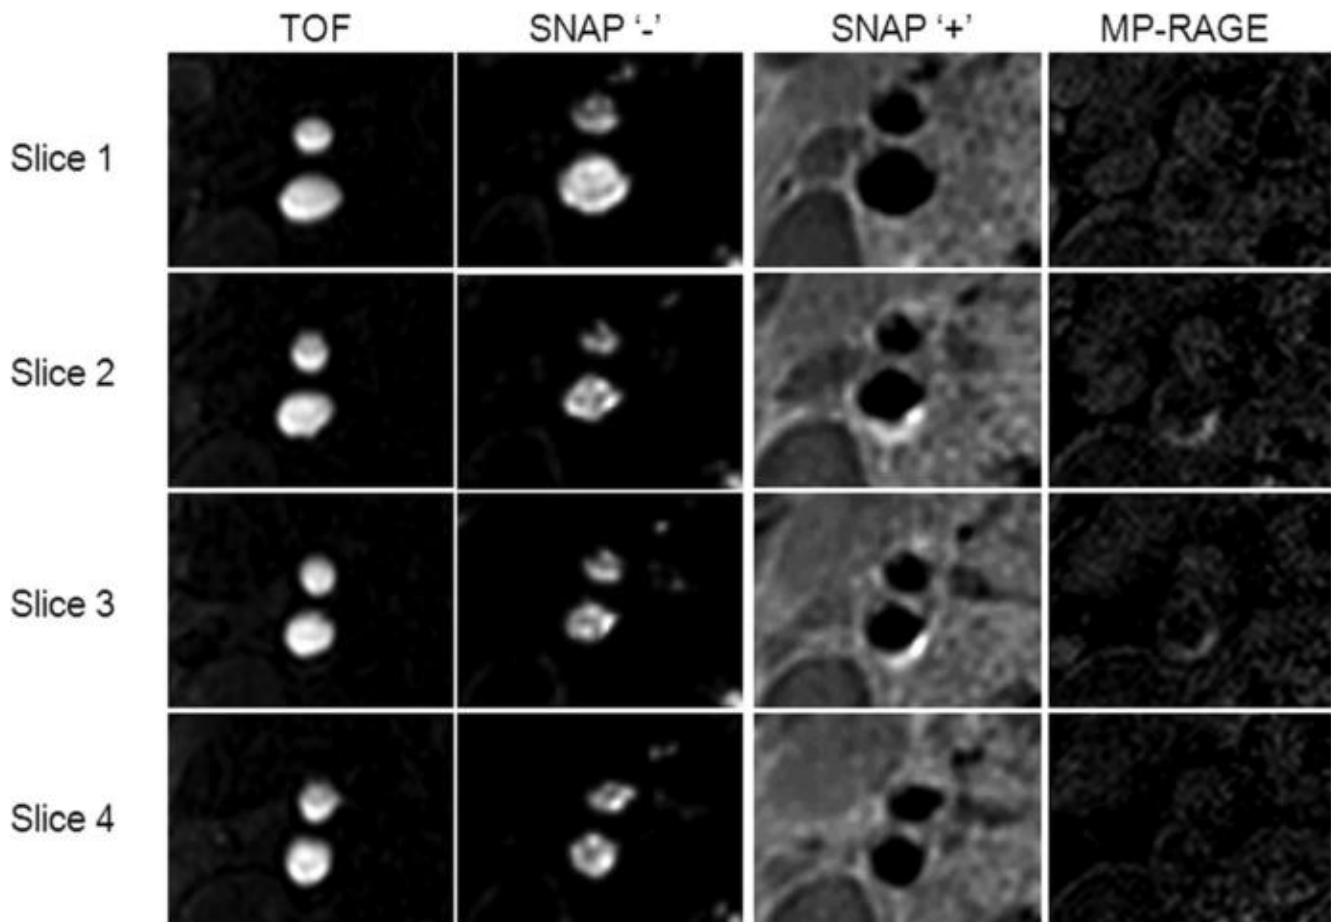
SNAP MRI can image angiography and intraplaque hemorrhage simultaneously. The angiography was comparable with TOF while the intraplaque hemorrhage detection had good agreement with MP-RAGE with higher IPH-to-wall contrast and better blood suppression compared with MP-RAEG.
